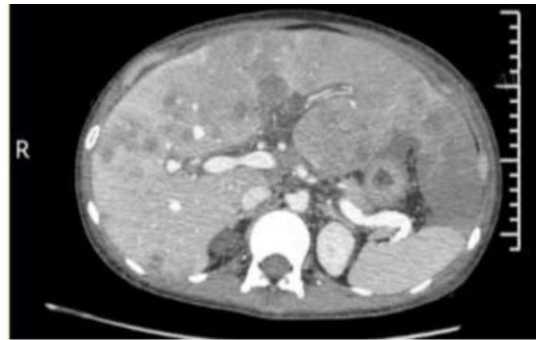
Enhanced computed tomography of upper abdomen and pelvic cavity of case 1 showed liver, bone and lymph node metastasis. The MRI of anal canal of case 1 showed anal cancer
